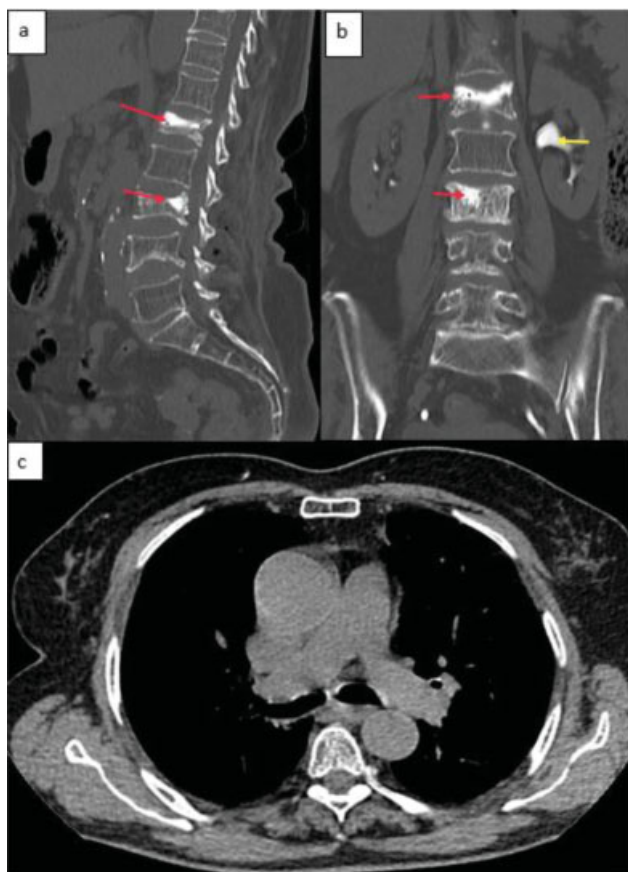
Postprocedure computed tomography (CT) images sagittal (a) and coronal (b) reconstruction show two levels, that is, L1 and L3 vertebral compression fracture treated successfully with percutaneous vertebroplasty (red arrow) excreted contrast in renal pelvicalyceal system (yellow arrow) injected intravenously to obtain venogram to visualize the sites of leak. (c) postprocedure CT thorax study does not demonstrate pulmonary embolism.
